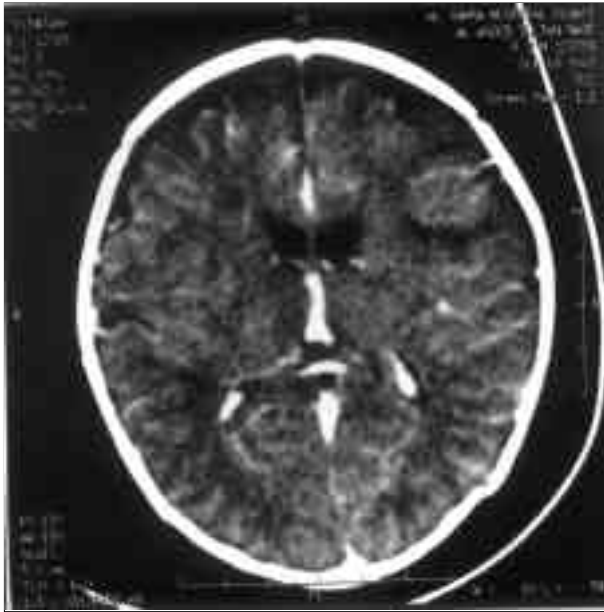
Plain CT Head shows widened subarachnoid spaces.
